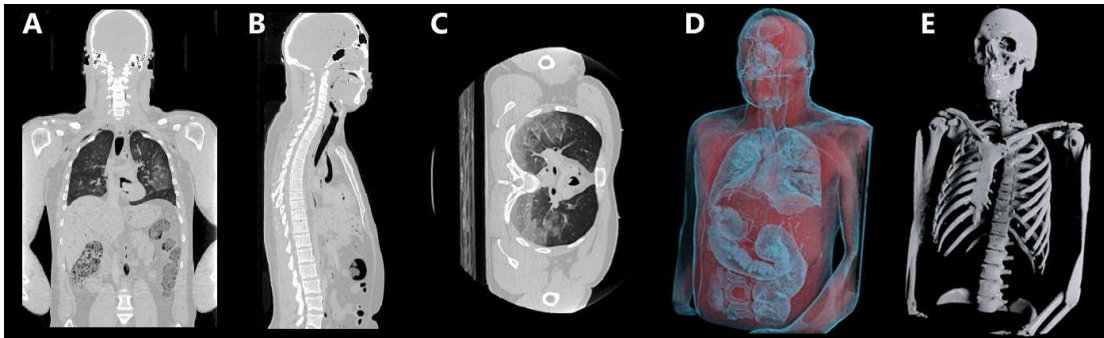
2D slices (A, B, C) and 3D visualisation (D, E) of the Visible Human Male dataset (section 9.7), showing the anatomical information provided by CT.
